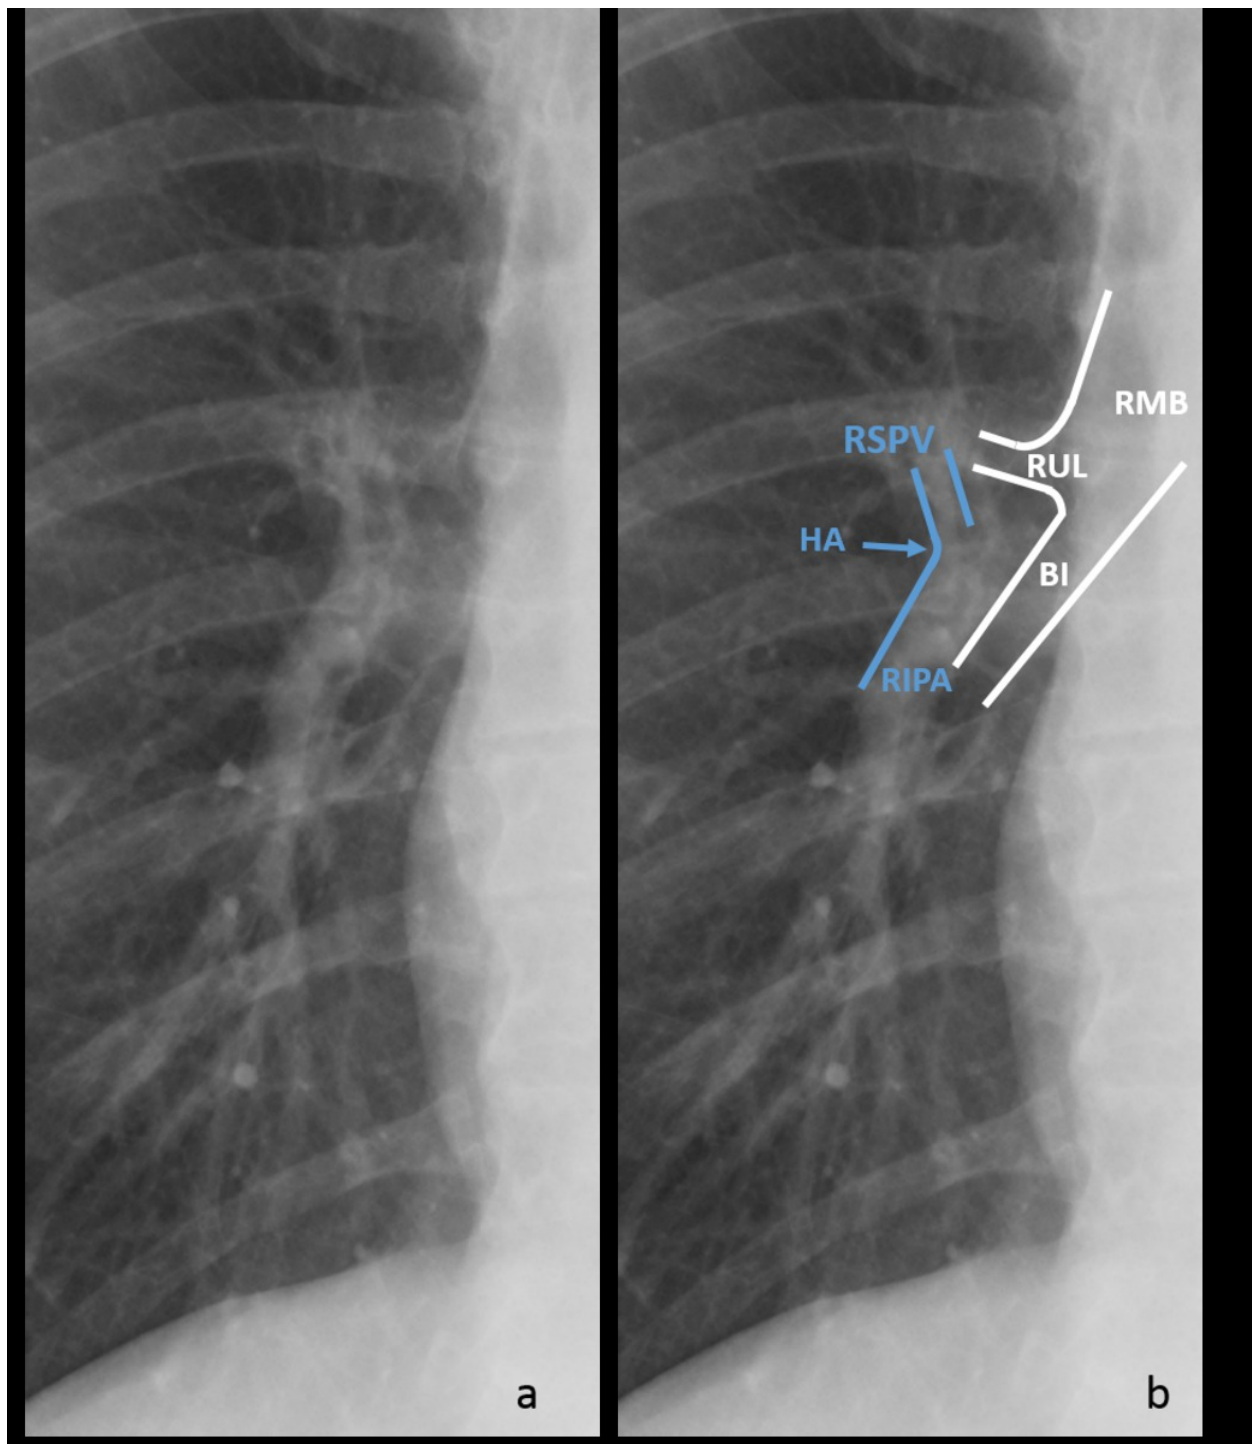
Normal right hilum in a plain radiograph (a) and the corresponding anatomical representation (b). HA: Hilar angle; RSPV: Right superior pulmonar vein; RIPA: Right inferior pulmonar artery; RMB: Right main bronchus; RUL: Right upper lobe bronchus; BI: Bronchus intermedius
